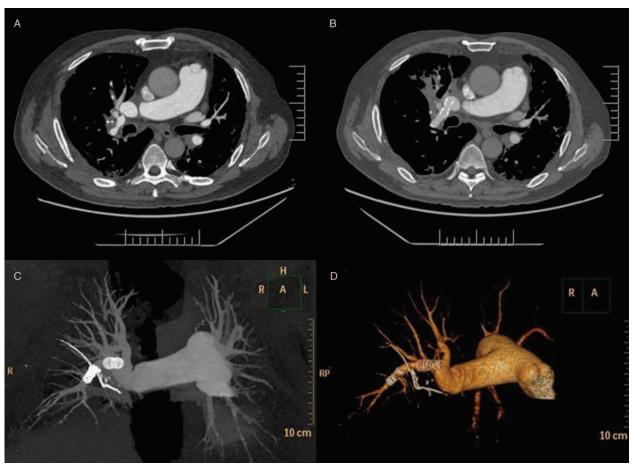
Pulmonary artery computed tomography angiography imaging and three-dimensional reconstruction results. (A) Computed tomography angiography imaging of the recipient showed stenosis at the right lower pulmonary trunk. (B) Computed tomography angiography imaging showed no apparent narrowing after the stents implantation. (C and D) Three-dimensional reconstruction results of the pulmonary artery after the stents implantation (stents and stapled line are highlighted).
